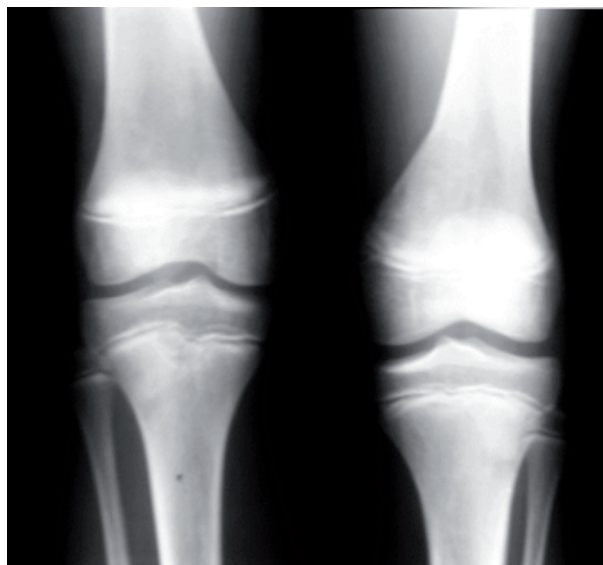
Preoperative X-ray picture of the knee joint in AP projection showing the shortening of the right lower limb in the patient planned for femur and tibia epiphysiodesis?
